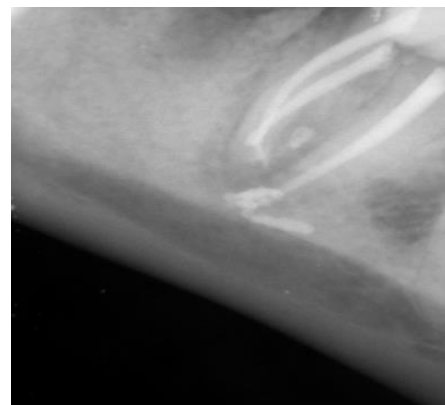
Immediate post-operative periapical radiograph showing sealer extrusion
